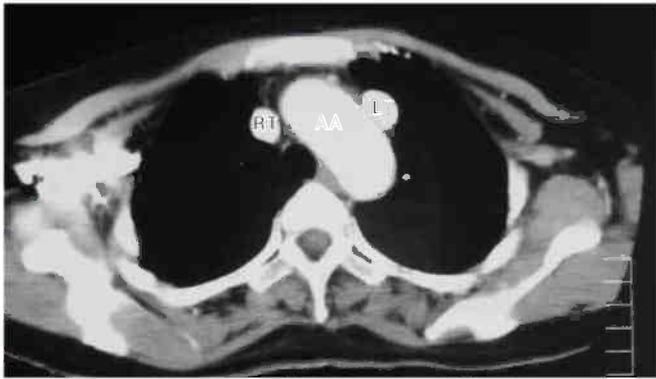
Axial CT image shows a persistent left (LT) superior vena cava next to the aortic arch (AA), with a normal right (RT) superior vena cava.
